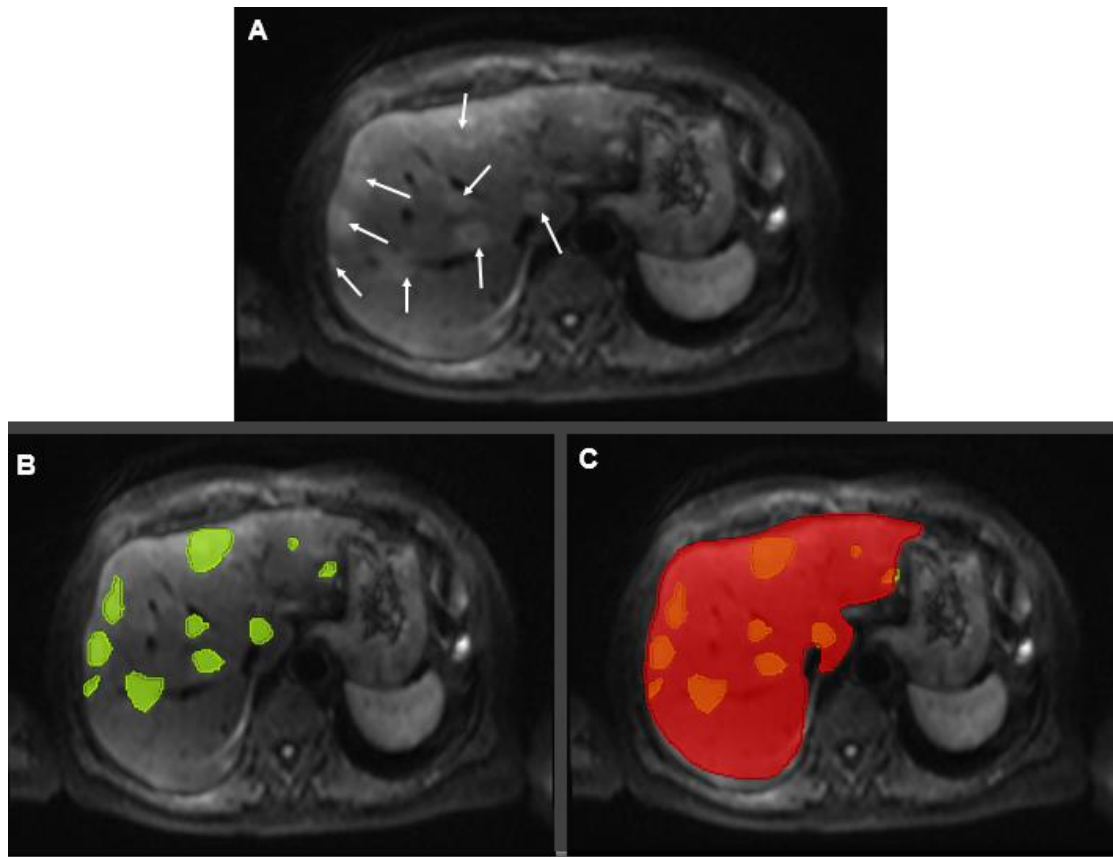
Example of manual segmentation of the liver and NELMs on a DWI sequence. (A) Original DWI image, the white arrows indicate the NELMs (not fully listed); (B) manual segmentation of the NELMs (green); (C) the overlapping of the segmentation of the liver (red) and the NELMs (green). Manual segmentation was performed on the DWI images with $b=400 \text{ s/mm}^2$.
